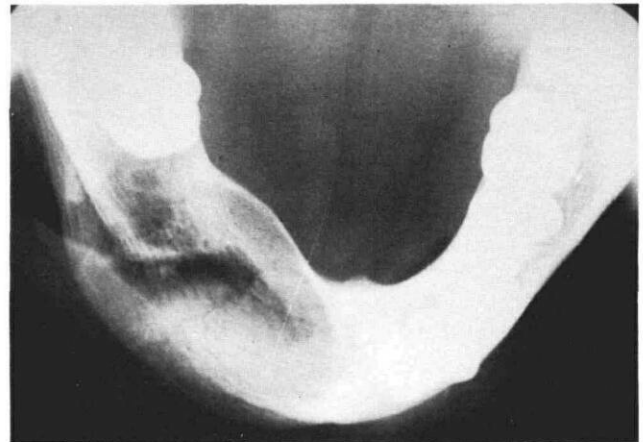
Radiograph of right lower mandible 1 year postoperatively, showing bone regeneration with partial remodeling (Patient 1).
